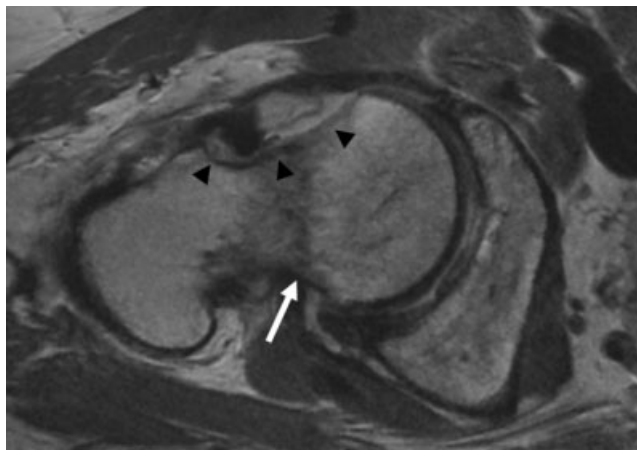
Oblique axial MR image of a 51-year-old woman with femoroacetabular impingement and osteoporosis 1 month after neck debridement (arrowheads) demonstrates a femoral neck fracture (arrow).
